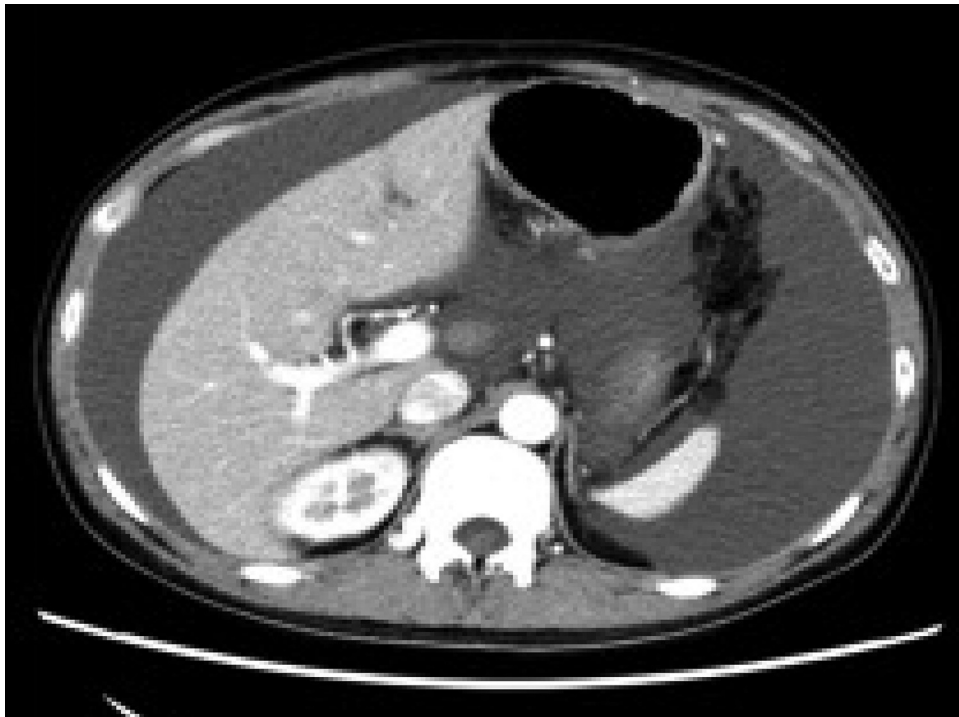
Abdominal computed tomography showing significant ascites.
